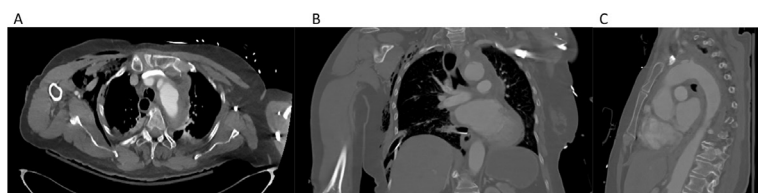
Initial chest CT scan demonstrating an aortic pseudoaneurysm with periaortic hematoma in the axial (A), coronal (B), and sagittal (C) planes.
